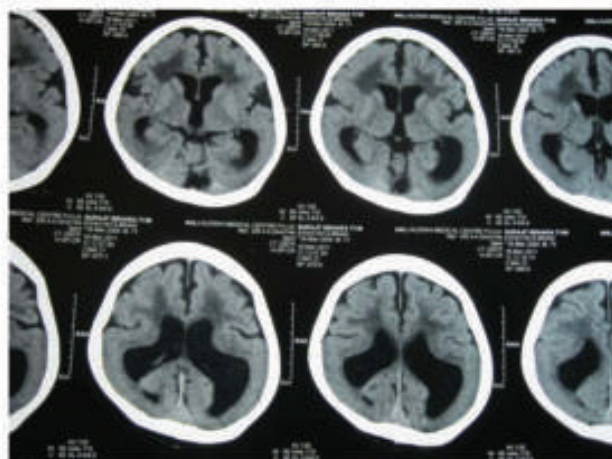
CT Scan of the younger brother
